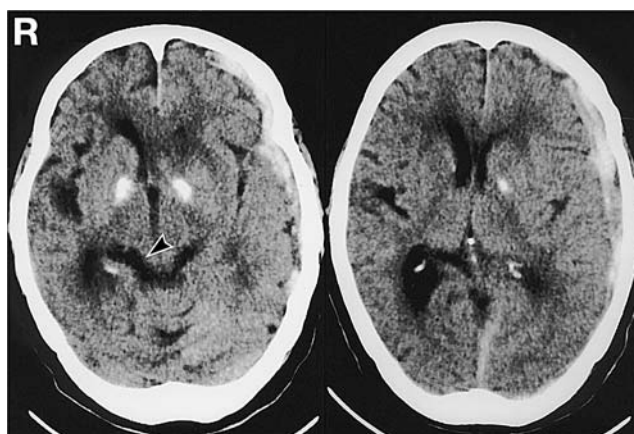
Computed tomography scans taken 2 days after admission revealing marked diminution of the hematoma. The midline shift had partially improved and the contralateral ambient cistern (arrowhead) was identified.
